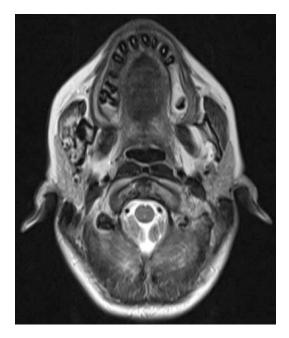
Cavernous hemangioma. MRI T2-W image of Fig. 18.42 reveals heterogeneous signal with signal-void areas which is characteristic for intraosseous cavernous hemangiomas
